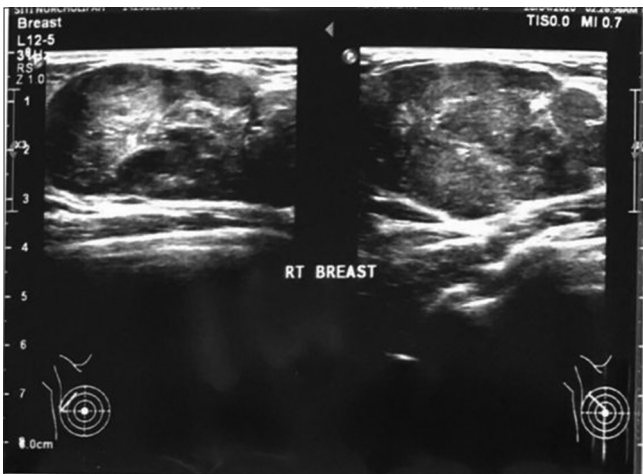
The ultrasound on the right breast before vacuum-assisted breast biopsy
